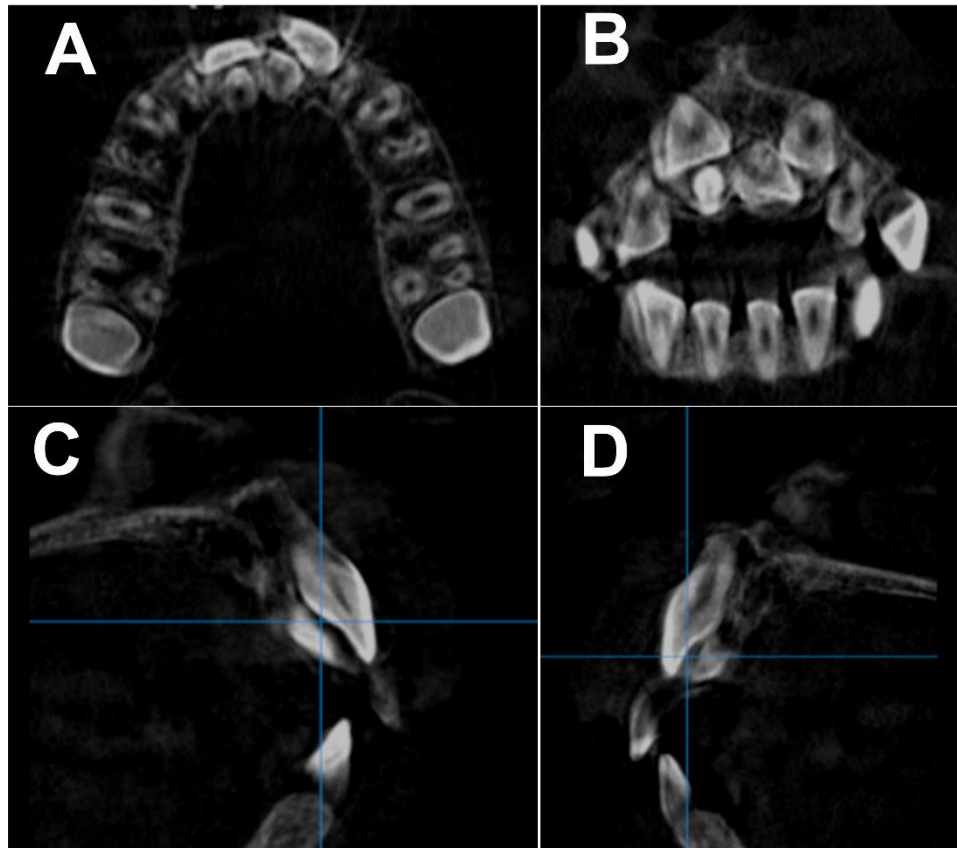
CBCT showing the impacted upper central incisors and a pair of tuberculated supernumerary teeth, in: (A) axial, (B) coronal and (C, D) sagittal views.
